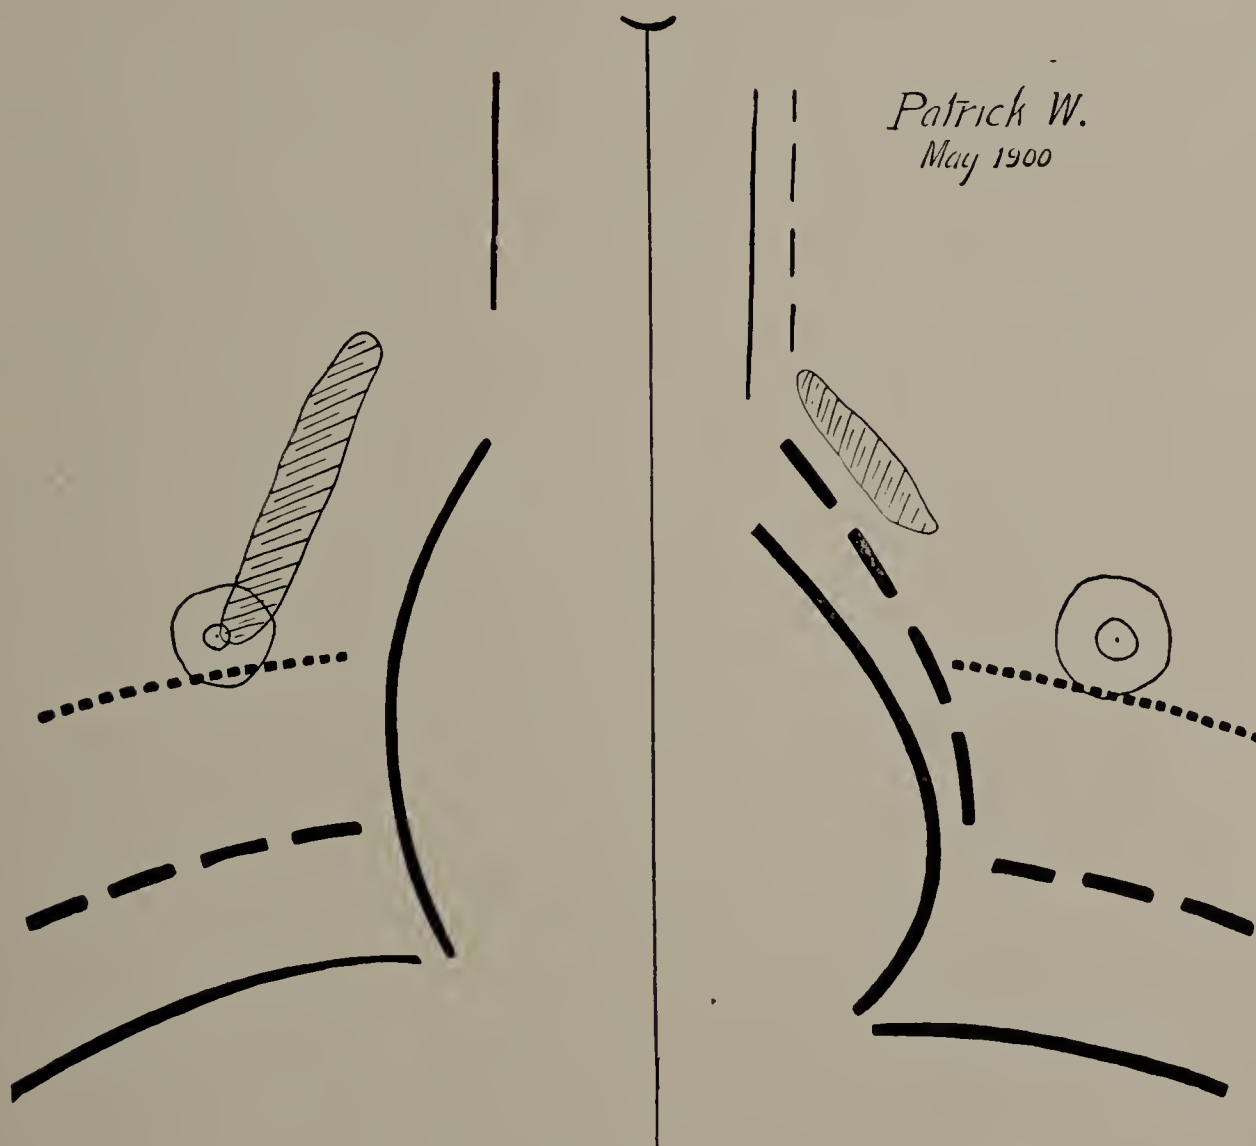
Patrick W. May 13, 1900. Third X-ray tracing. Apex of right lung clear, showing that the shaded area was probably not due to tuberculosis but perhaps to remains of acute pneumonia. Broken and full parallel lines indicate position of diaphragm in expiration and inspiration respectively; dotted lines parallel to them, diaphragm line in forced expiration. (One-third life size.)
